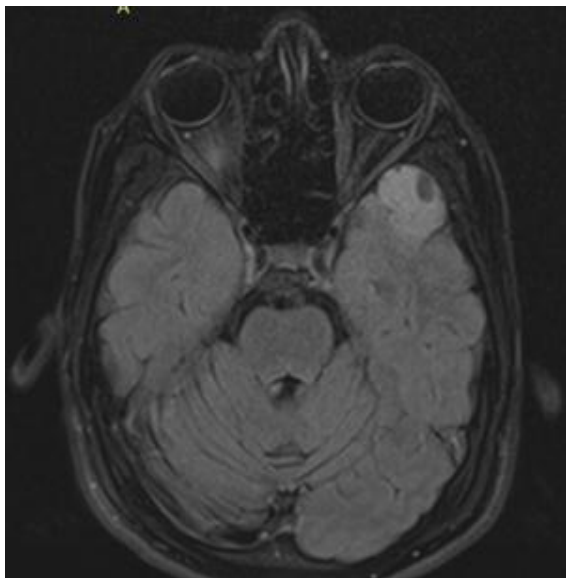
MRI revealed a well-defined lesion in the left anterior temporal lobe.
